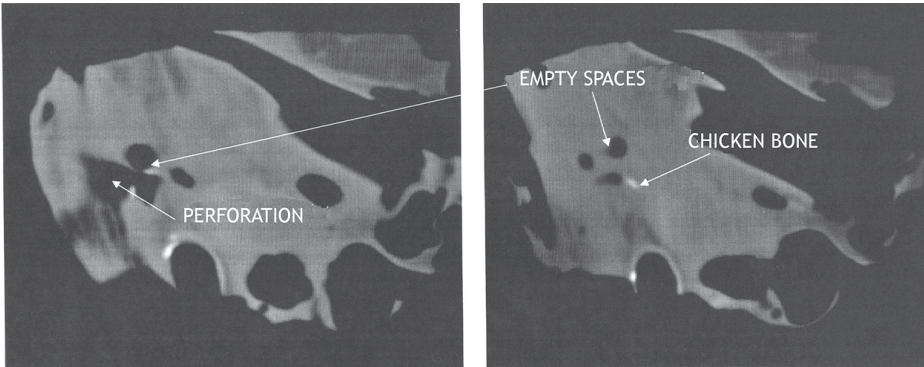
Computed Tomography findings. Empty spaces into mediastinal soft tissues in relation with chicken bone and esophageal perforation.
